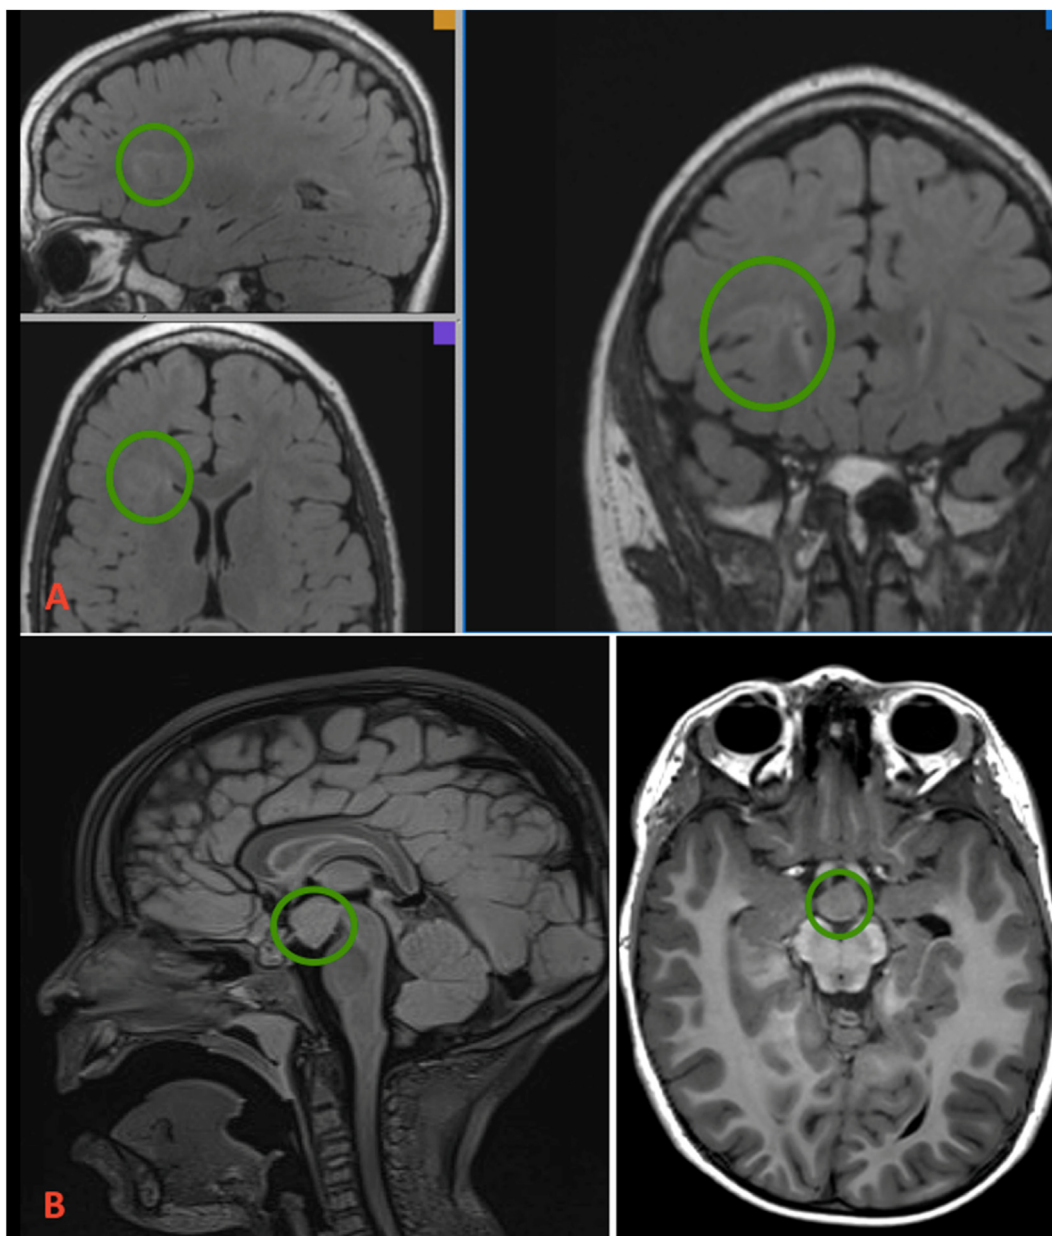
Magnetic resonance images showing epileptogenic lesion (green circles) for Patient 1 (A)—focal cortical dysplasia at the right frontal and dorsal anterior insula—and for Patient 2 (B)—hypothalamic hamartoma at tuber cinereum. The color version of this figure is available in the online edition.
